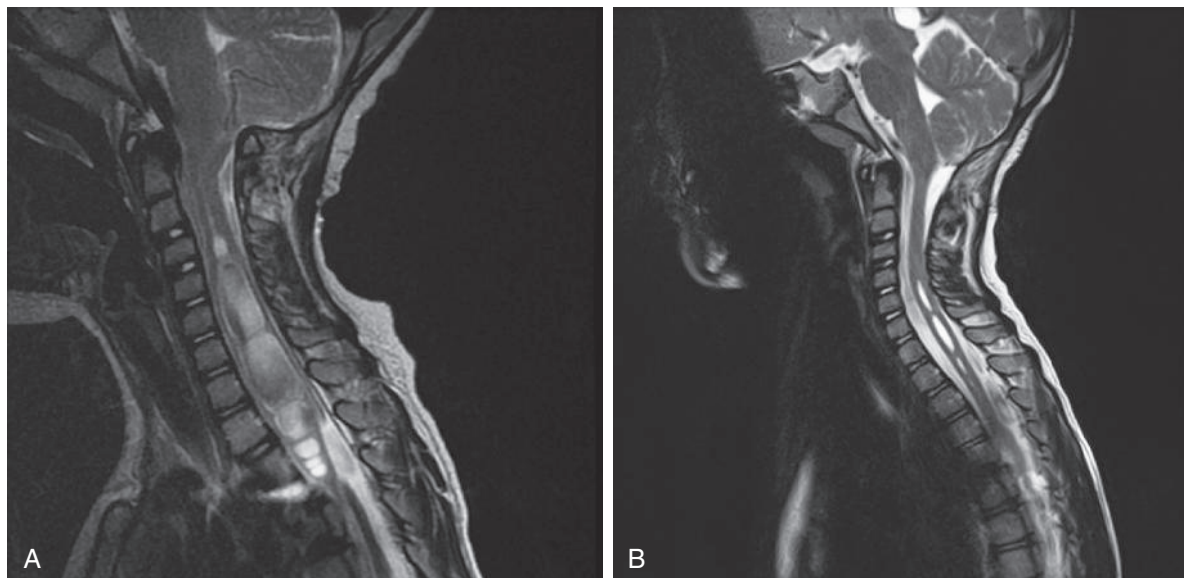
A, Child with Chiari I malformation and preoperative syrinx. B, Postoperative magnetic resonance image showing improvement of this patient's syrinx.
